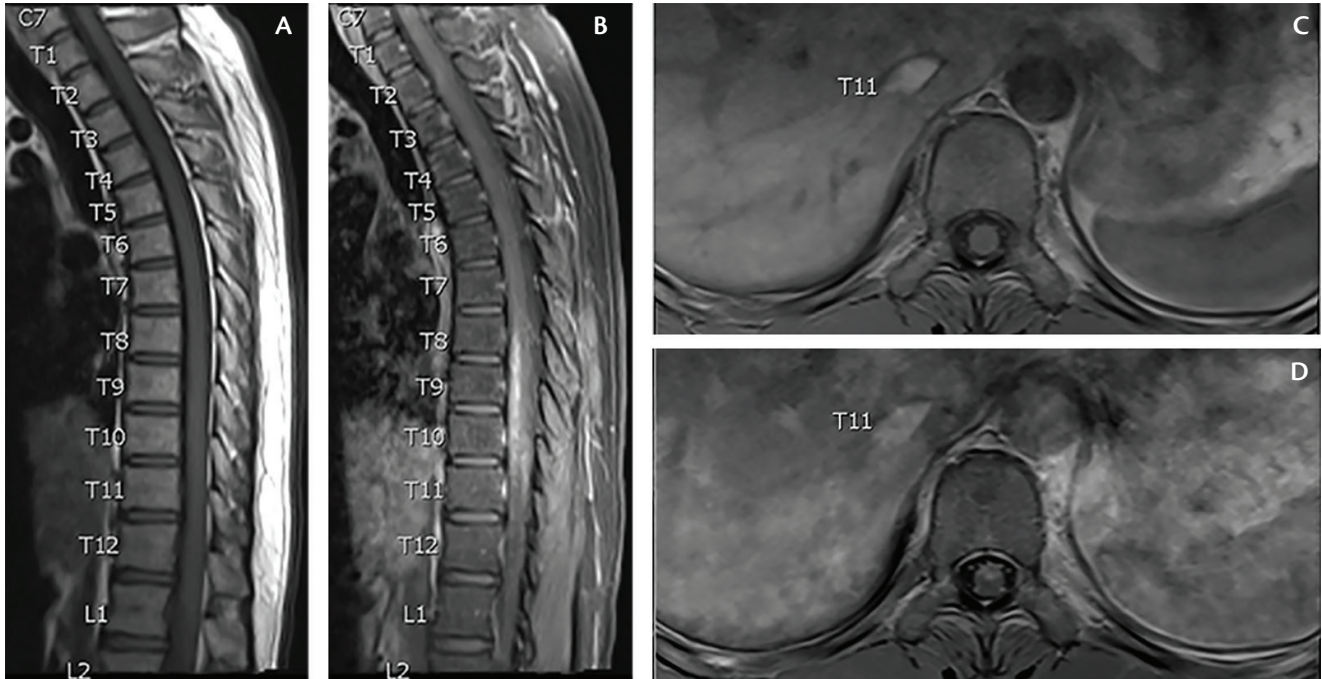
Sagittal T1 pre- (A) and postcontrast (B) MRI of the thoracic and lumbar spine showing anterior cord enhancement from T8 through T11 and axial T1 pre- (C) and postcontrast (D) MRI showing enhancement of the conus medullaris and nerve roots from T2 through L1.
